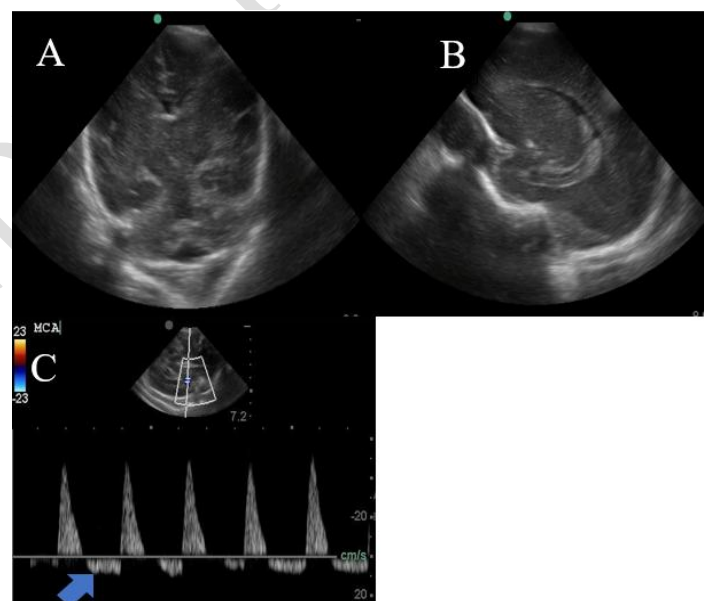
(A-C images): (A): coronal scan through the quadrigeminal cistern, and (B): sagittal scan through the body of lateral ventricle show normal ultrasound
